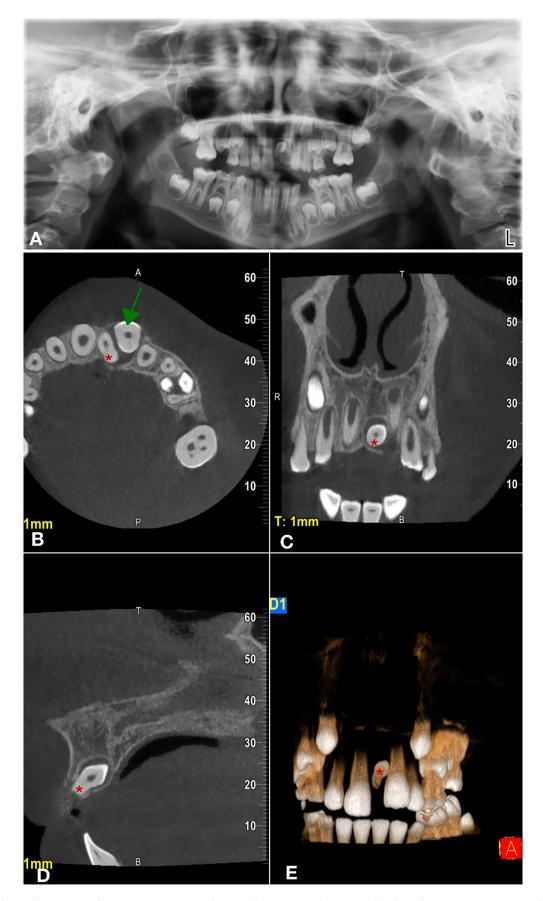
Radiographs of a sample case showing mesiodens causing complications in permanent teeth. (A) Panoramic radiographic image. Mesiodens was observed in the midline. (B) Axial CBCT image. Eruption problems and hyperplastic follicle were observed in tooth number #21. (C) Coronal CBCT image. (D) Sagittal CBCT image. Mesiodens was observed in the midline inverted position. (E) 3D reconstruction image (green arrows pointed to tooth #21, red stars pointed to mesiodens).
